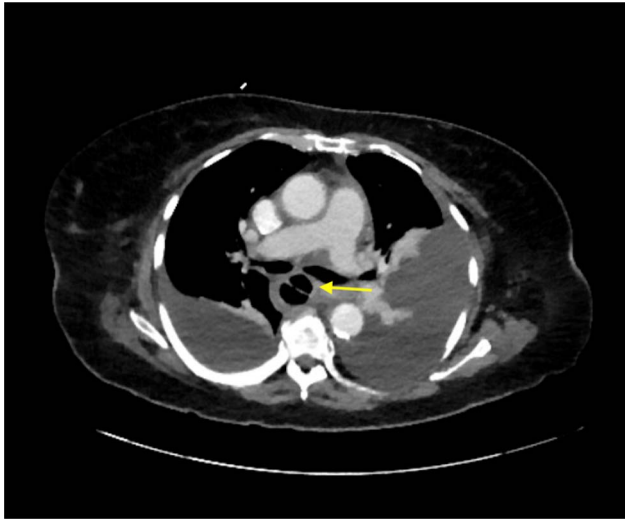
Repeat chest computed tomography with resolution of the mass and pre-esophageal lumen.
